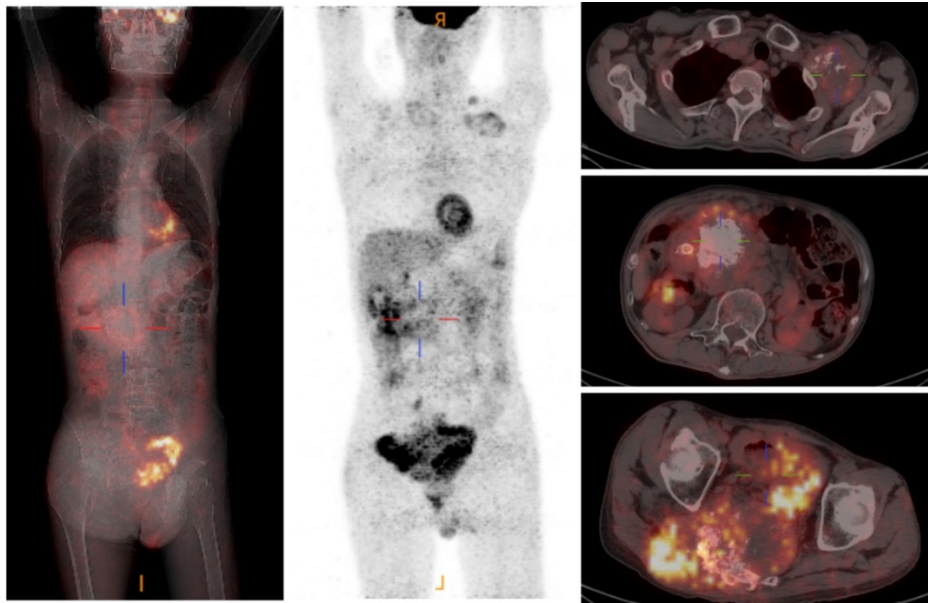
Positron emission tomography (PET)/CT showed multiple high-density calcifications and abnormally increased FDG metabolism throughout the body.
